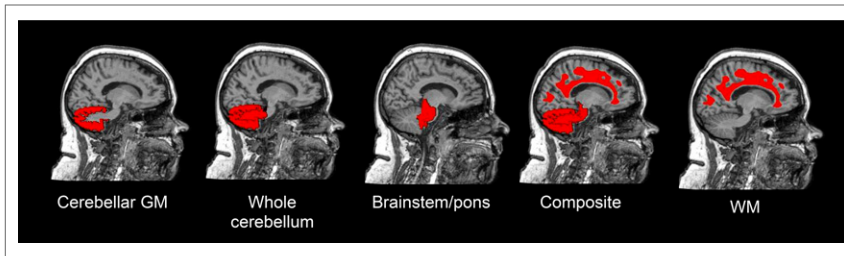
Candidate reference regions for florbetapir analysis are overlaid on an example subject's MR imaging scan.
